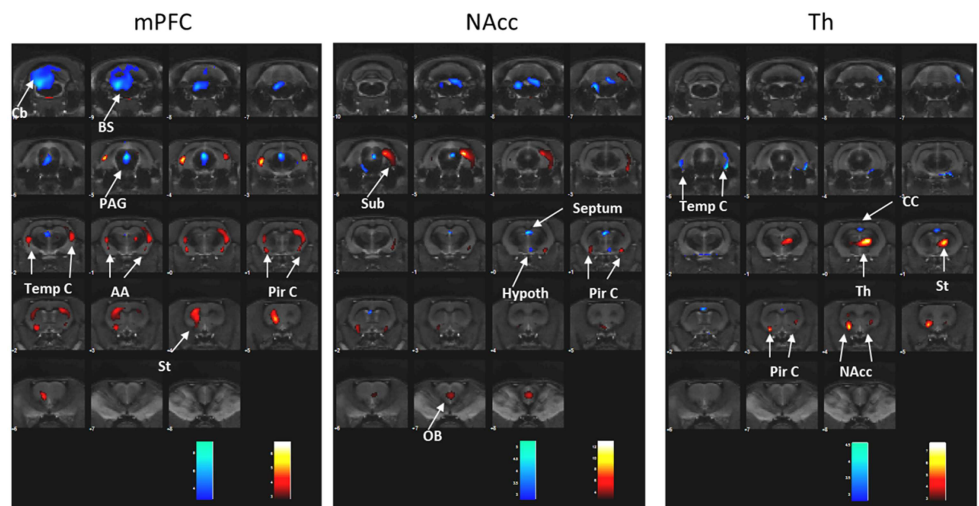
Brain glucose metabolism during DBS in the three brain targets. Effects depend on stimulation target. Colored PET overlays on MR reference indicate increased ^{18}F FDG uptake (hot colors) or decreased (cold colors). AA: amygdala; BS: brainstem, Cb: cerebellum, CC: cingulate cortex, Hypoth: hypothalamus, NAcc: nucleus accumbens, PAG: periaqueductal gray matter, Pir C: piriform cortex, Sub: subiculum hippocampal, Str: striatum, Temp C: temporal cortex, Th: thalamus.
